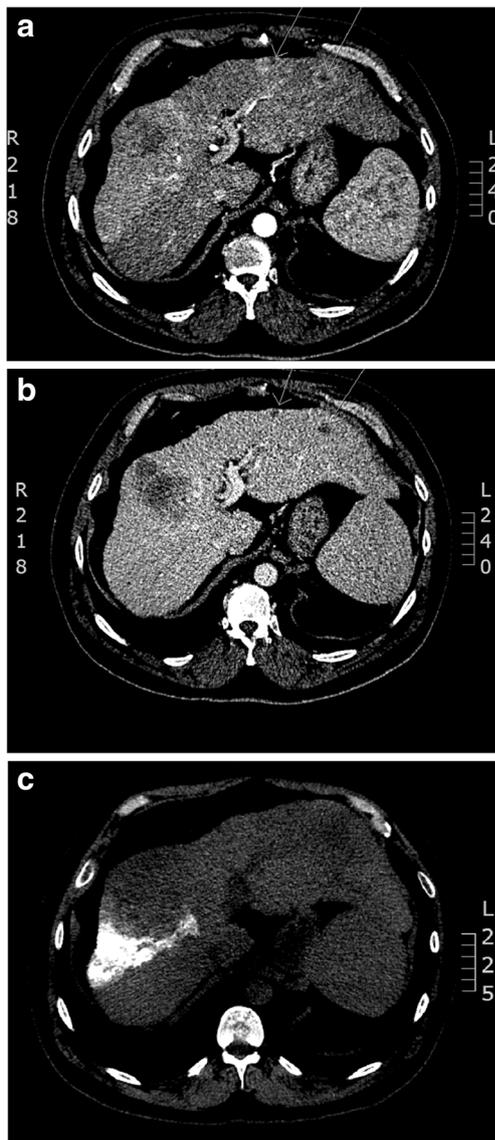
a CT scan 6 months later with increased size of prior arterially enhancing lesion with new adjacent arterially enhancing lesions with central hypodensity (arrows) b and subsequent venous washout. c CT scan immediately post TACE treatment showing accumulation of lipiodol adjacent to large tumor in segment 8 with poor tumor uptake
